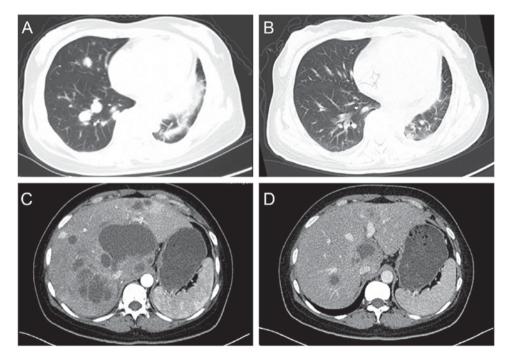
Examples of response to treatment with chemotherapy plus bevacizumab. CT images of a 51-year-old female with stage IV adenocarcinoma following (A) pre-treatment with chemotherapy-bevacizumab on 1st December, 2012 and (B) post-treatment with chemotherapy-bevacizumab on 6th February, 2013. CT images of a 42-year-old female with stage IV squamous cell carcinoma following (C) pre-treatment with chemotherapy plus bevacizumab on 9th May, 2015 and (D) post-treatment with chemotherapy-bevacizumab on 10th July, 2015. Images A and C were captured at baseline. Images B and D were captured following 2 cycles of chemotherapy-bevacizumab.
